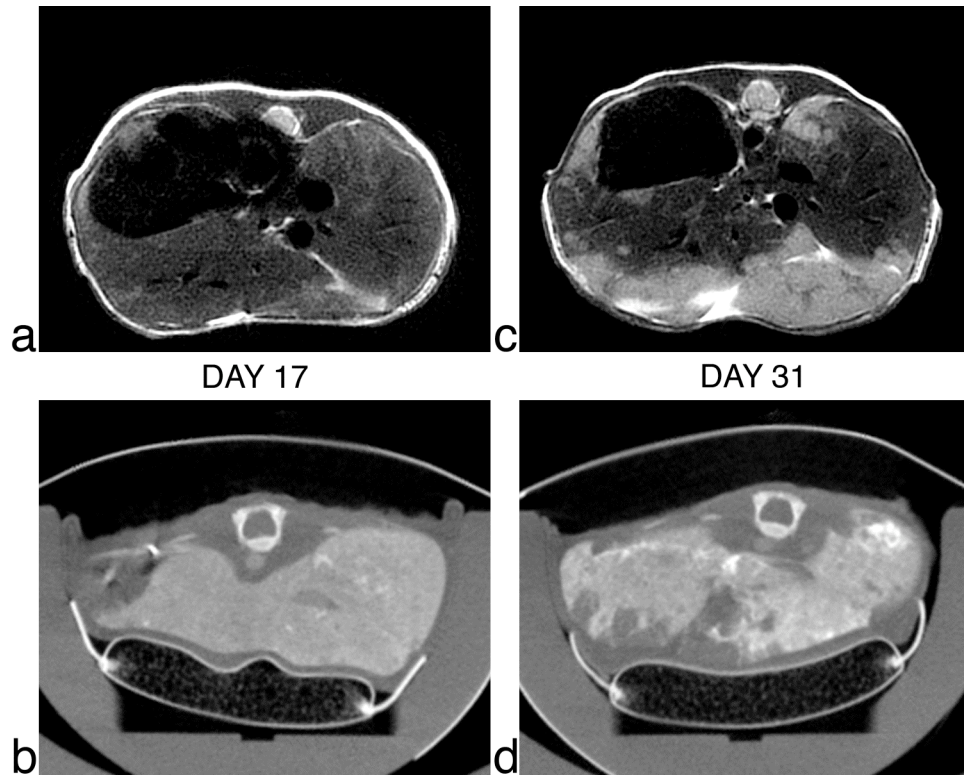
Representative slices from MR (top) and CT (bottom) datasets acquired at an early (a, b) and late (c, d) timepoint during the longitudinal study. In-plane resolution = 125 μm , slice thickness = 1 mm. Ungated, T_2 -weighted MR datasets (a, c) were acquired with 2-shot PROPELLER in 30 minutes. Contrast-enhanced, respiratory-gated CT datasets (b, d) were acquired in 6 minutes.
